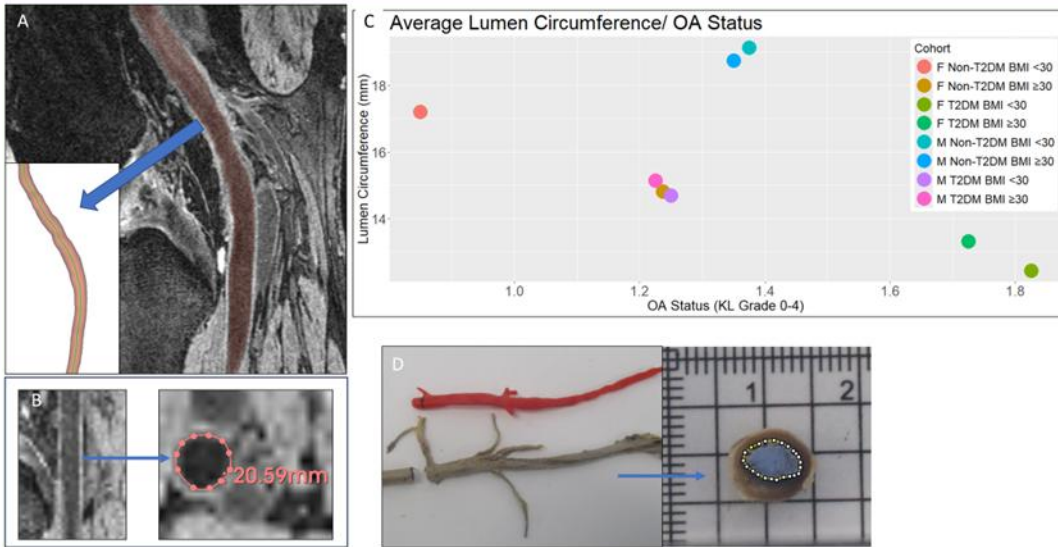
3D Reconstruction of lumen used to orientate each MRI slice to centreline (A). Axial view of straightened volume used to measure lumen (B). Popliteal luminal circumference vs Kellgren Lawrence Grade of 160 patients (20 patients per cohort, left and right knee) (C). Popliteal artery was dissected and cut at specific landmarks to measure luminal circumference and verify accuracy of method (D)
